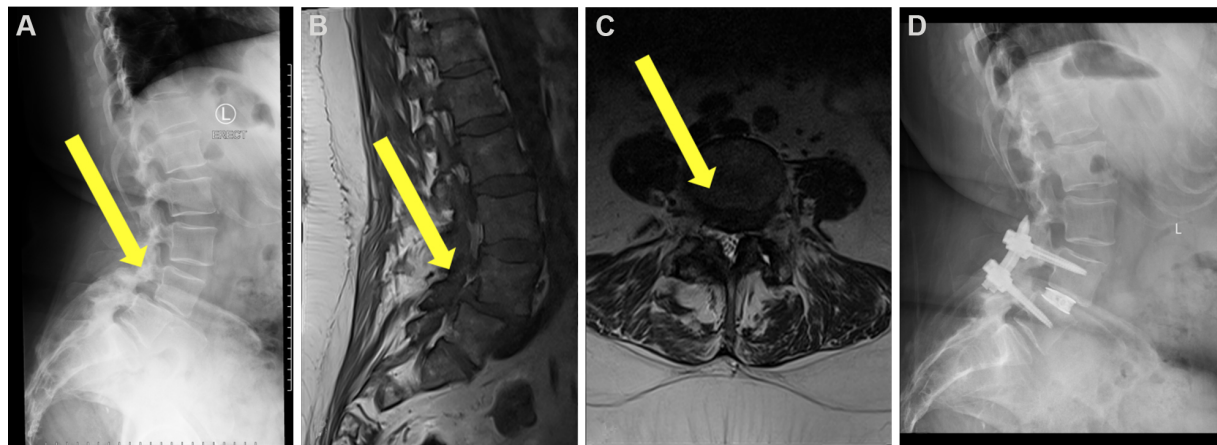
Patient 24. Treatment of degenerative spondylolisthesis of L4/5. (A) Preoperative lateral radiograph, (B) preoperative mid-sagittal magnetic resonance imaging slice, (C) preoperative coronal slice at pathology, (D) postoperative lateral radiograph.
